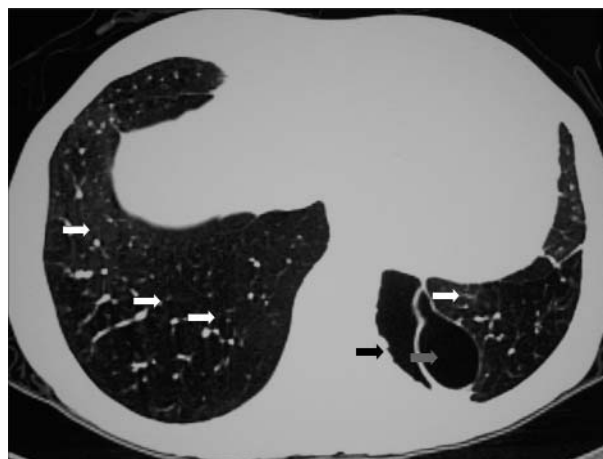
Computed tomography-thorax demonstrating bronchiolitis obliterans (white arrows – widespread areas of low attenuation lung parenchyma, peripheral bronchioles and vessels), left lower lobe collapse (black arrow) and adjacent left base cystic bullae (grey arrow).
